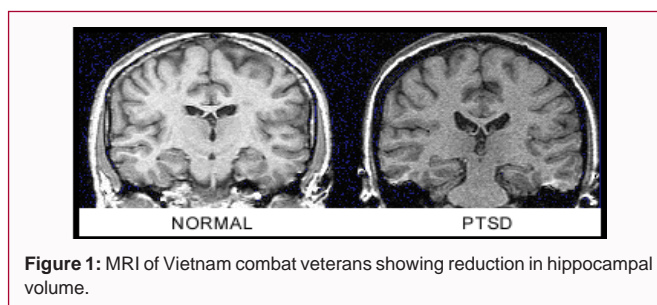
MRI of Vietnam combat veterans showing reduction in hippocampal volume.
